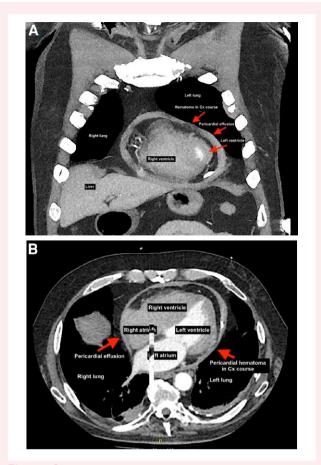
(*A* and *B*) Thoracic computed tomography revealed haemorrhagic pericardial effusion with delineation of a contrast medium in the area of the left circumflex (LCx) that exceeds the myocardial contour (haematoma).
